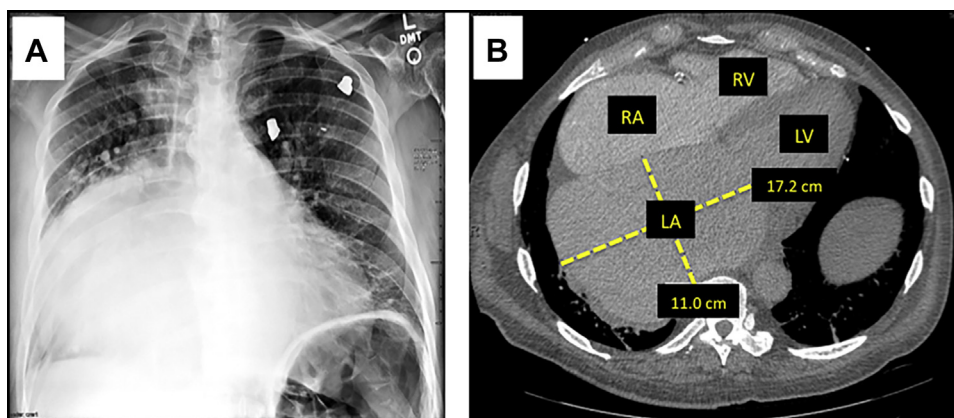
(A) This chest film showed severe cardiomegaly and pulmonary vascular congestion. The right border of the heart is prominent and obscures the right lung field. Two bullet fragments were found incidentally in the left lung field. (B) Computed tomography of the chest revealed enlargement of all 4 cardiac chambers. Notice the massive enlargement of the left atrium (LA). LV = left ventricle; RA = right atrium; RV = right ventricle.
